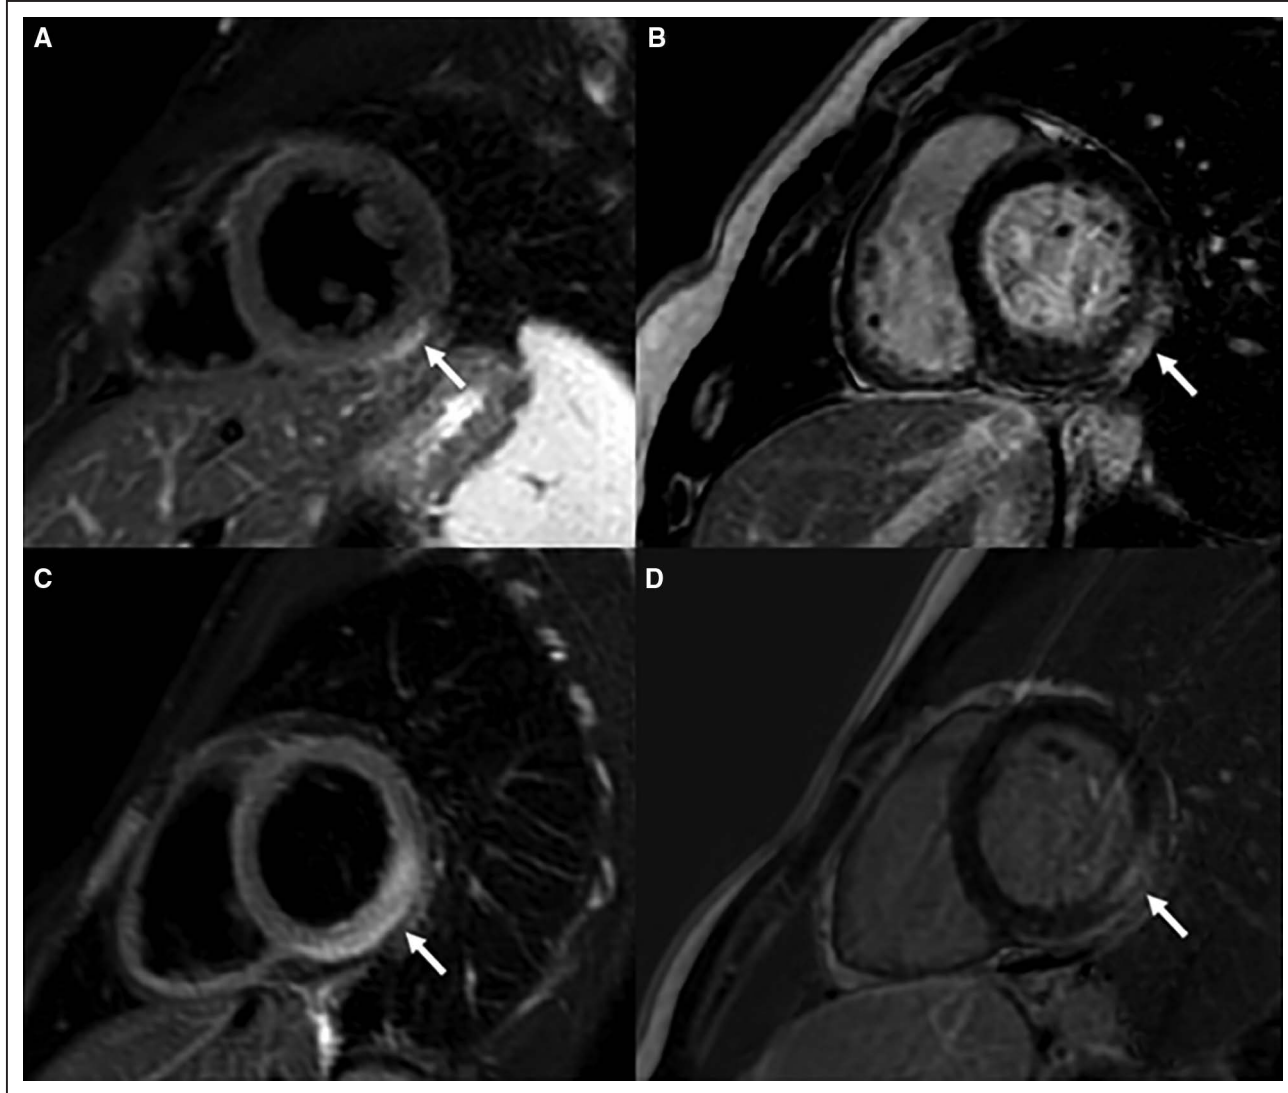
Cardiac magnetic resonance images from a 16-year-old boy (A and C) obtained 5 days after second dose (2 days after symptom onset) and a 15-year-old boy (B and D) 4 days after second dose (2 days after symptom onset).
